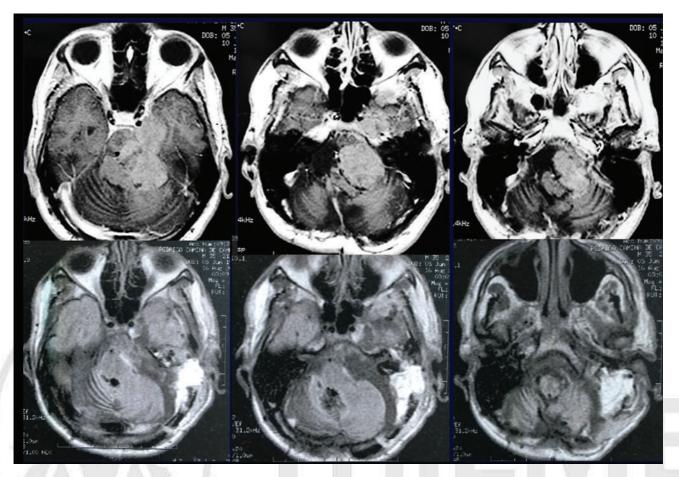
Meckel's cave meningioma. Above: preop MRI of a giant Meckel's cave meningioma. Below: postop MRI presenting complete removal through a combined petrosal approach. MRI, magnetic resonance imaging.
